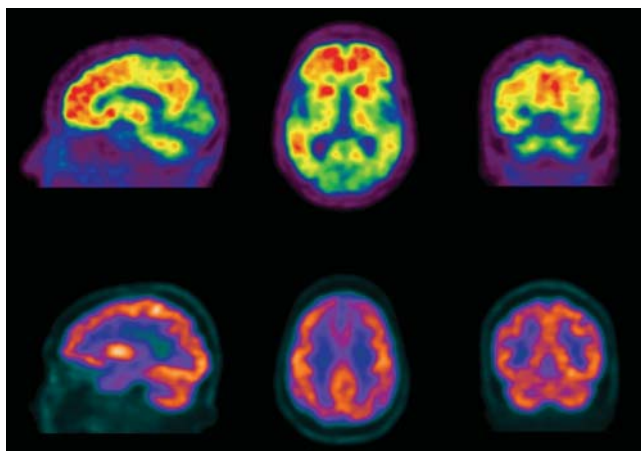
^{11}C -PIB accumulation on PET in an elderly individual with mild Alzheimer's disease (top), clearly showing uptake in the visual cortex, with ^{18}F -FDG images (bottom) providing less information.
